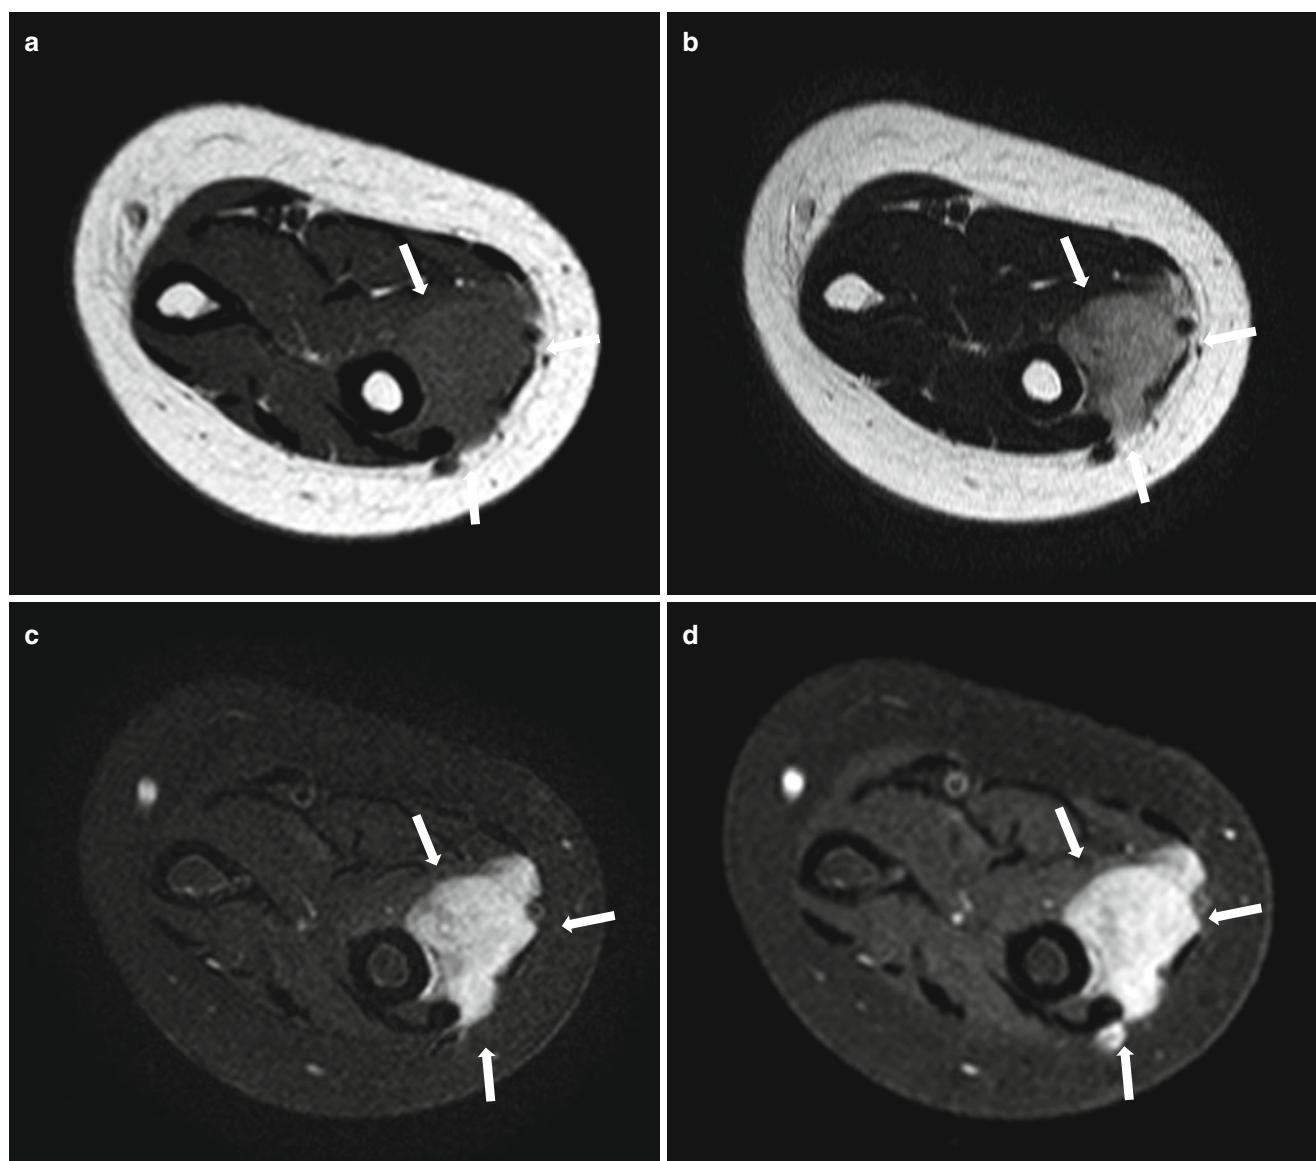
Synovial sarcoma in arm of a 10-year-old girl. (a) Axial T1-weighted MR image shows a mass (*arrows*) with isointense signal relative to muscle. (b) Axial T2-weighted MR image shows the lobulated border of the mass (*arrows*) with heterogeneously high signal
